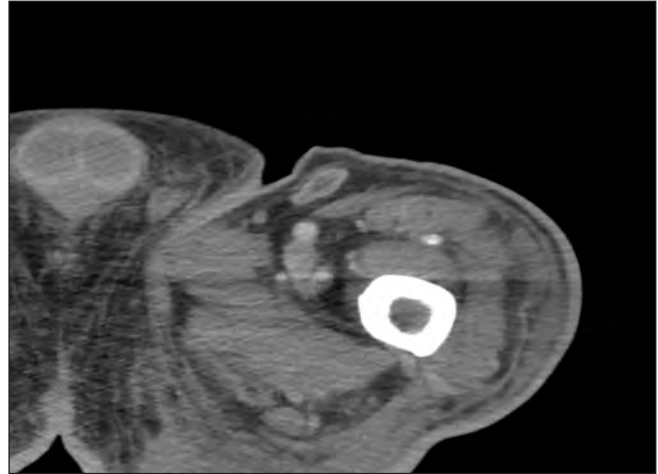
CT Scan of Left Thigh
